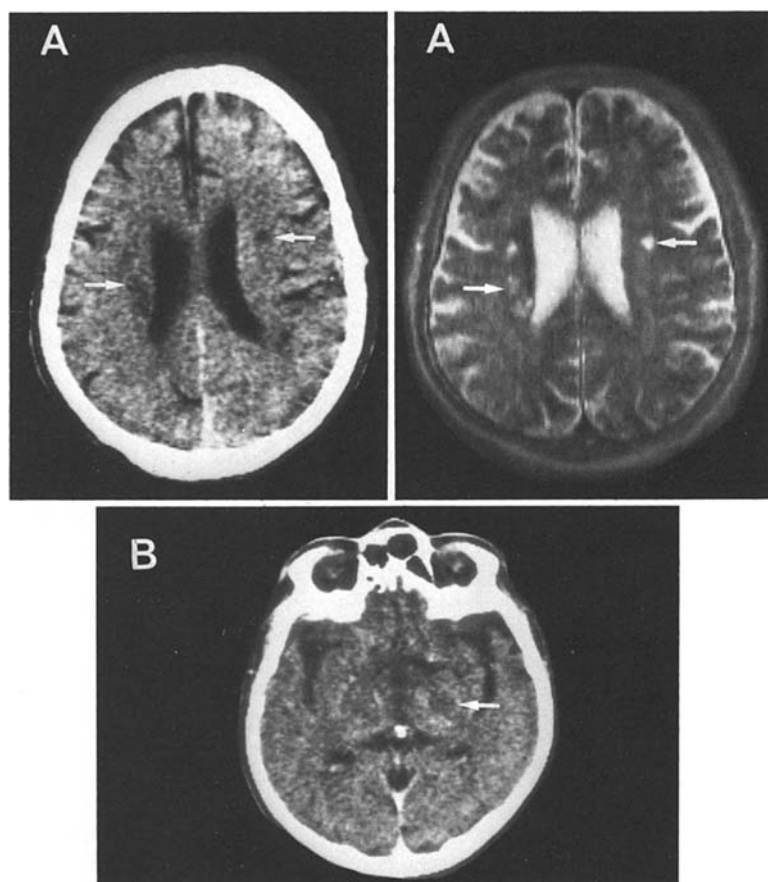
Computerized tomography and magnetic resonance imaging in two patients with extra-pontine manifestation of central pontine myelinolysis. CCT in A shows an area of low density with a corresponding increased image intensity in MR paraventricular bilaterally (arrows). CCT in B shows an area of low density in the right thalamus; MR imaging, performed 7 weeks after CCT examination; was normal. (A = patient 4, native CCT, MR: repetition time 4260 ms, time echo 120 ms; B = patient 5, contrast CCT)
